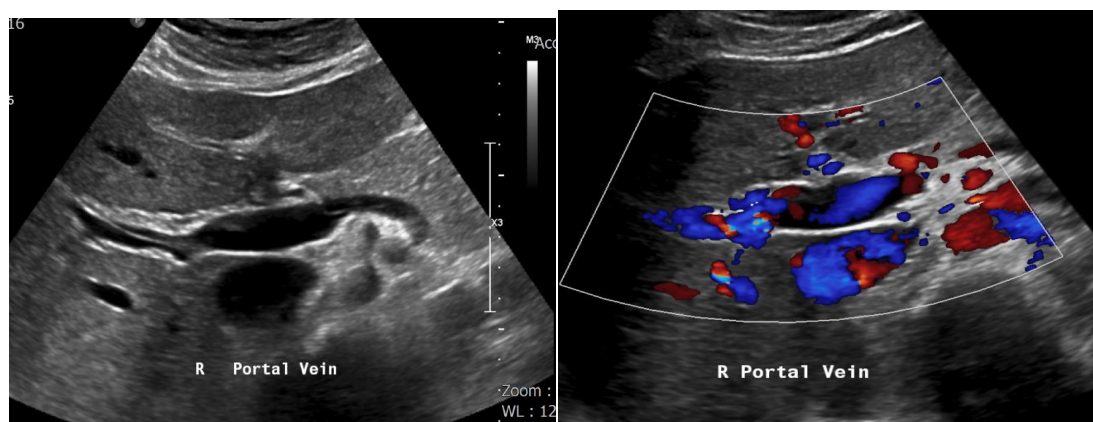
Repeat doppler ultrasound after 1 month of anticoagulant therapy, showed resolving of thrombus in the right portal vein and only seen minimal strands of remaining thrombus. Blood flow to this area improved as shown by colour doppler (left)
